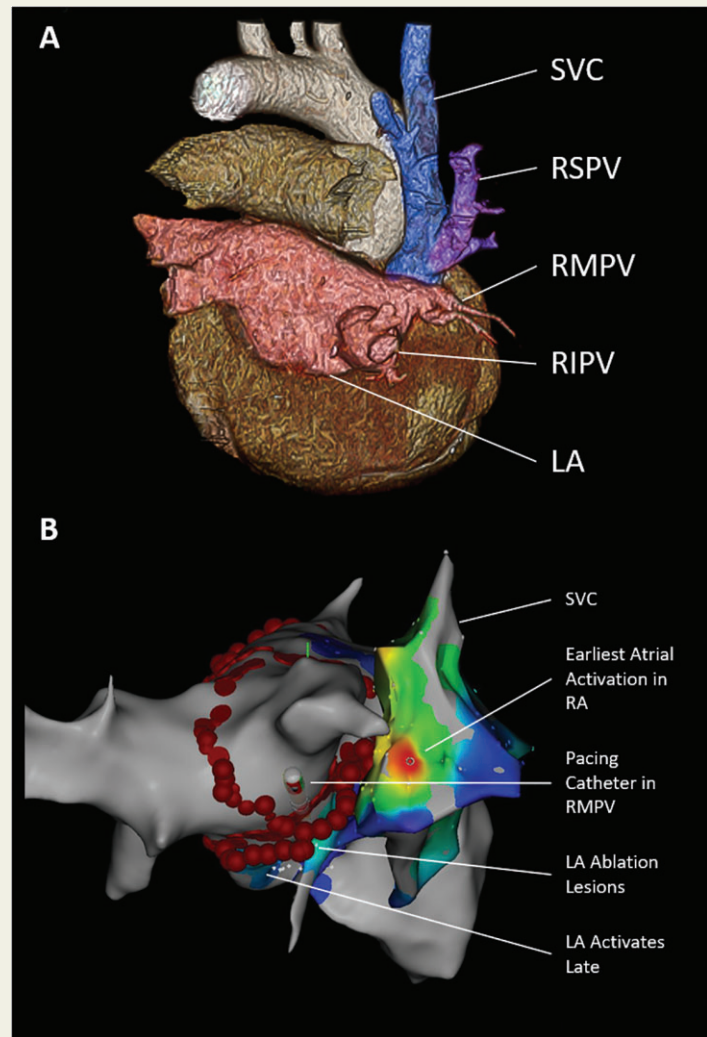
(A) Computed tomography reconstruction image demonstrating right superior pulmonary vein (RSPV) draining into the superior vena cava (SVC) and the right middle (RMPV) and inferior (RIPV) draining into the left atrium (LA). (B) Activation map performed during low output pacing within the RMPV with early activation of the high posterior right atrium (RA) and late activation of the LA following wide antral circumferential ablation, consistent with an epicardial RMPV to RA connection.
